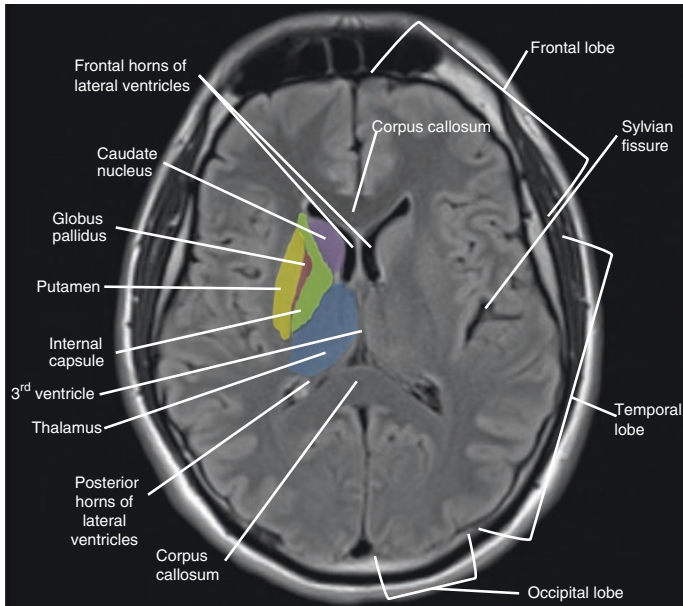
Basal ganglia (Flair sequence MRI brain)
